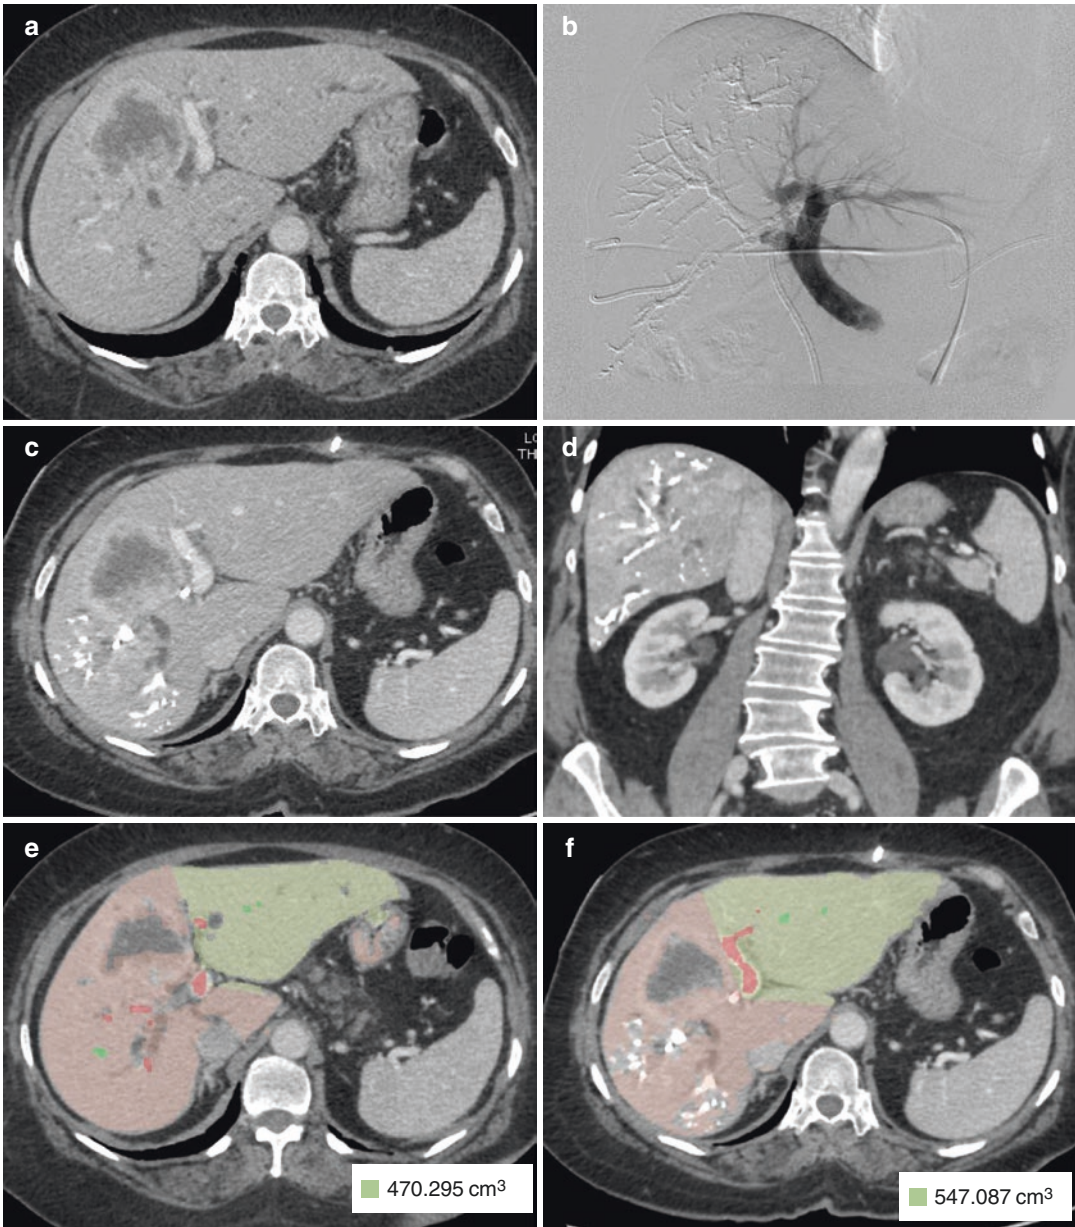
A 60 year female patient with cholangiocarcinoma underwent right portal vein embolization using contralateral approach. (a) Pre PVE, axial cross-section CT section shows mass forming cholangiocarcinoma. (b) DSA image shows right PVE done via contralateral approach with contrast
